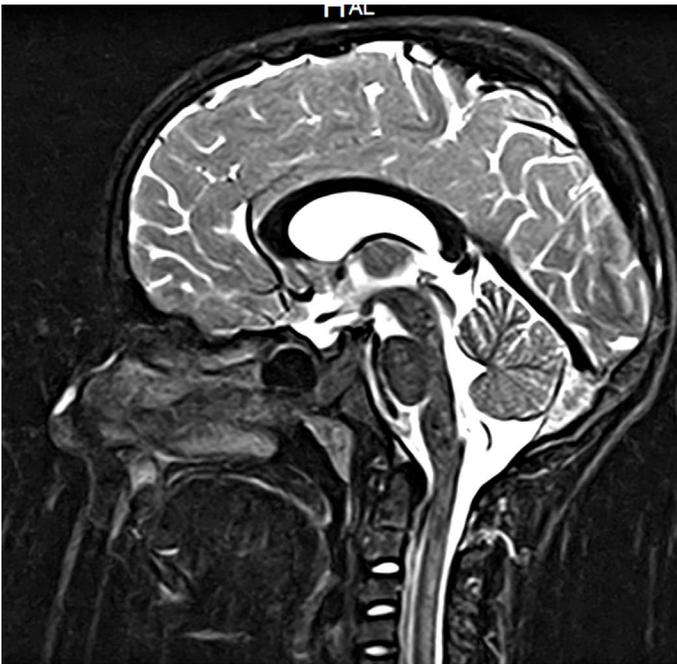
2b. MRI of the patient's head – sagittal scans.
